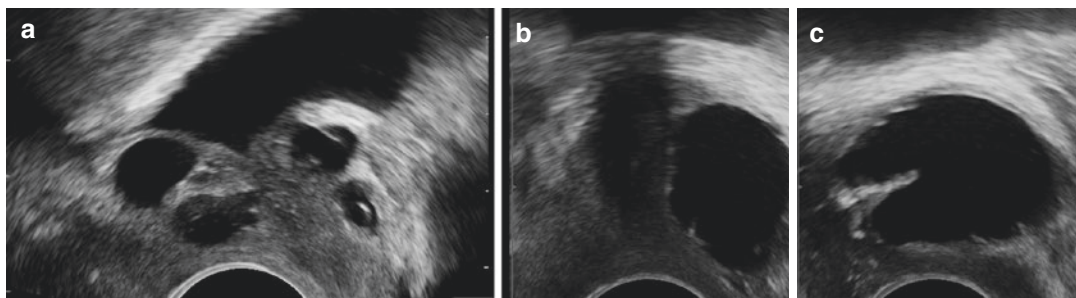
FUD using transvaginal in ultrasound, multiple (a) and single FUD (b, c)
